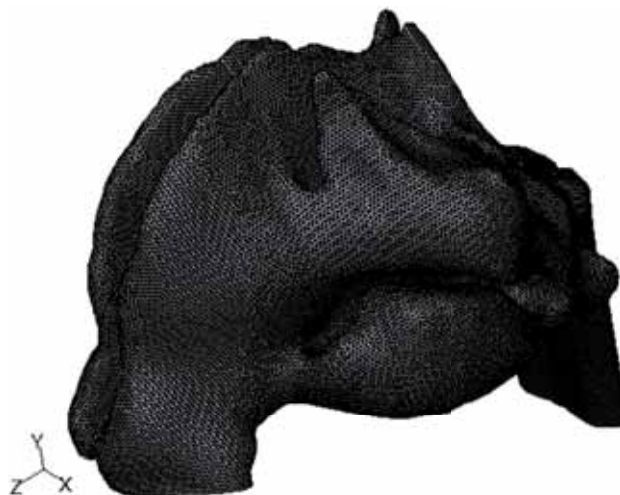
Tetrahedral mesh created from a CT scan.
